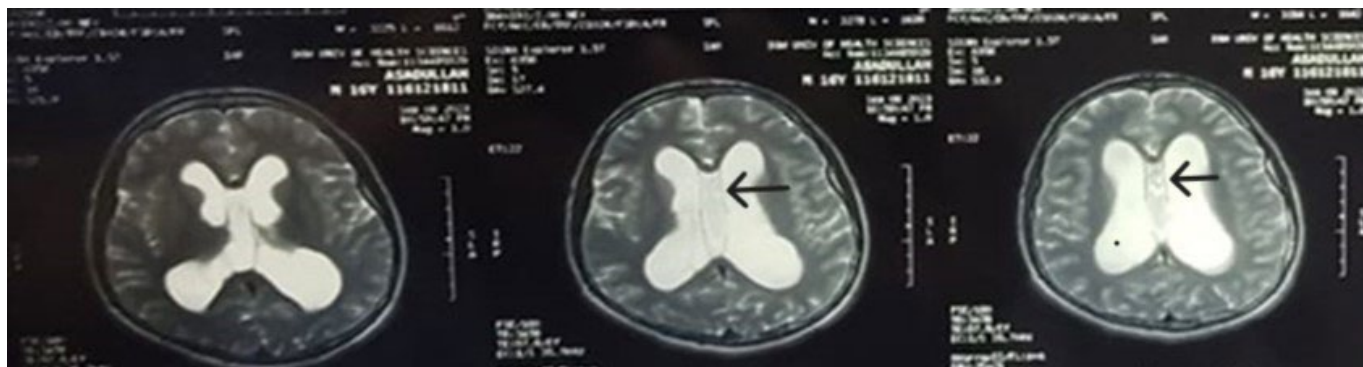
T2 Weighted MRI showing CSP cyst (arrow) cavum vergae, along with hydrocephalus.
